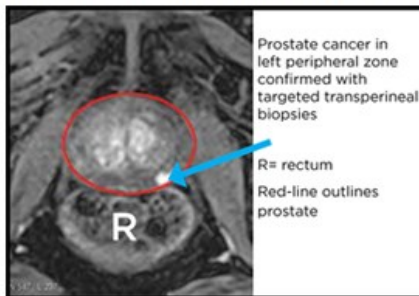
Multi-parametric MRI
